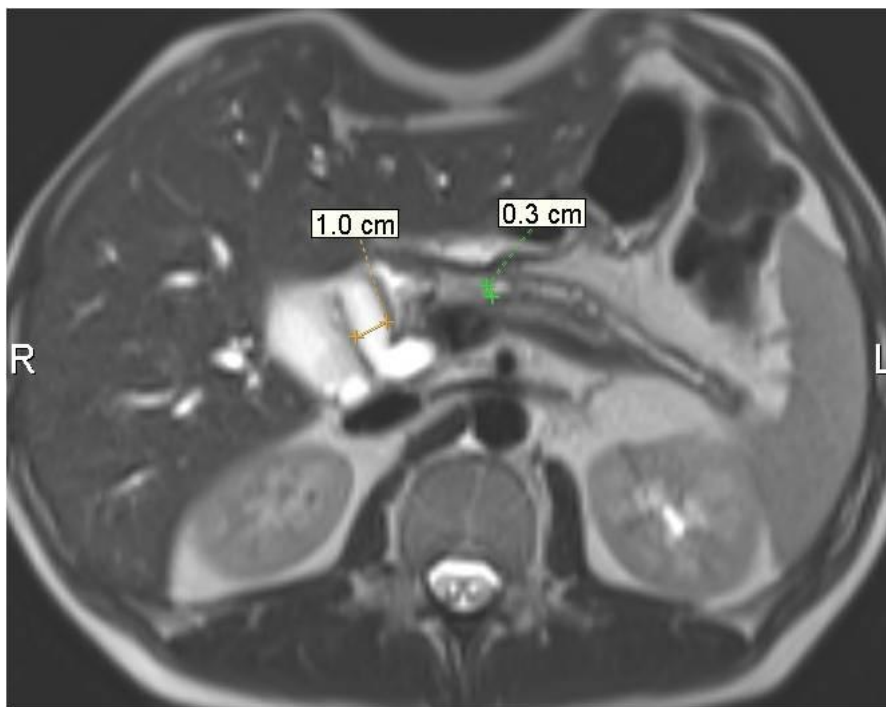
MRI of patient K. 19.01.2017 MR sequence T2VI, axial plane of scanning, FatSat (fat suppression). Expanded yegepatico choledocha and Virsungian duct.
